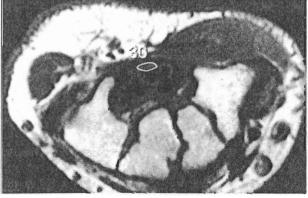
Axial T1-weighted MR image at the level of the hook of the hamate bone. Calculated outline of the cross-sectional area of the median nerve (30).
